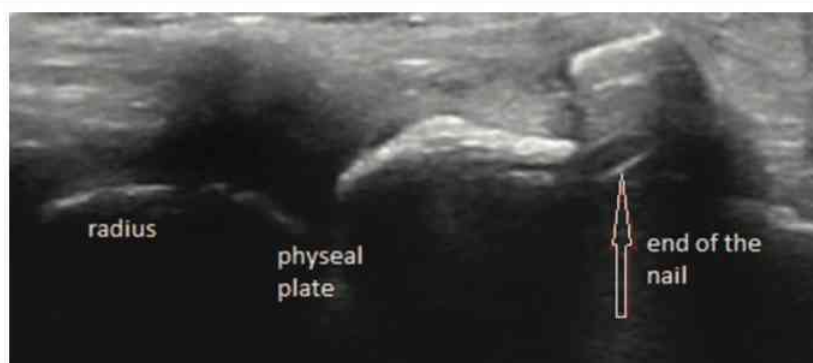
Longitudinal intraoperative sonographic view of the nail and the radius: Extensor pollicis longus tendon is not visualized.
